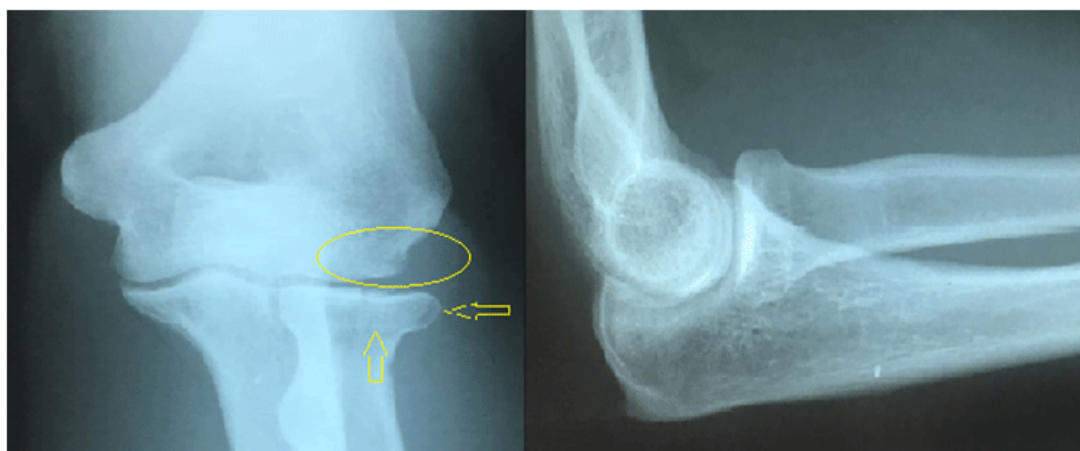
AP and Lateral X-ray of Left elbow showing a concomitant radial head and capitellar fractures.
